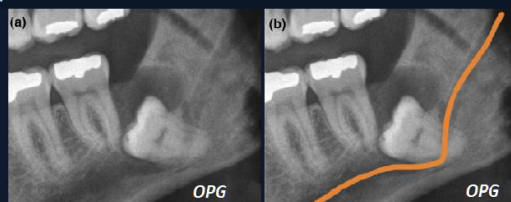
Information from OPG vs CBCT¹¹
